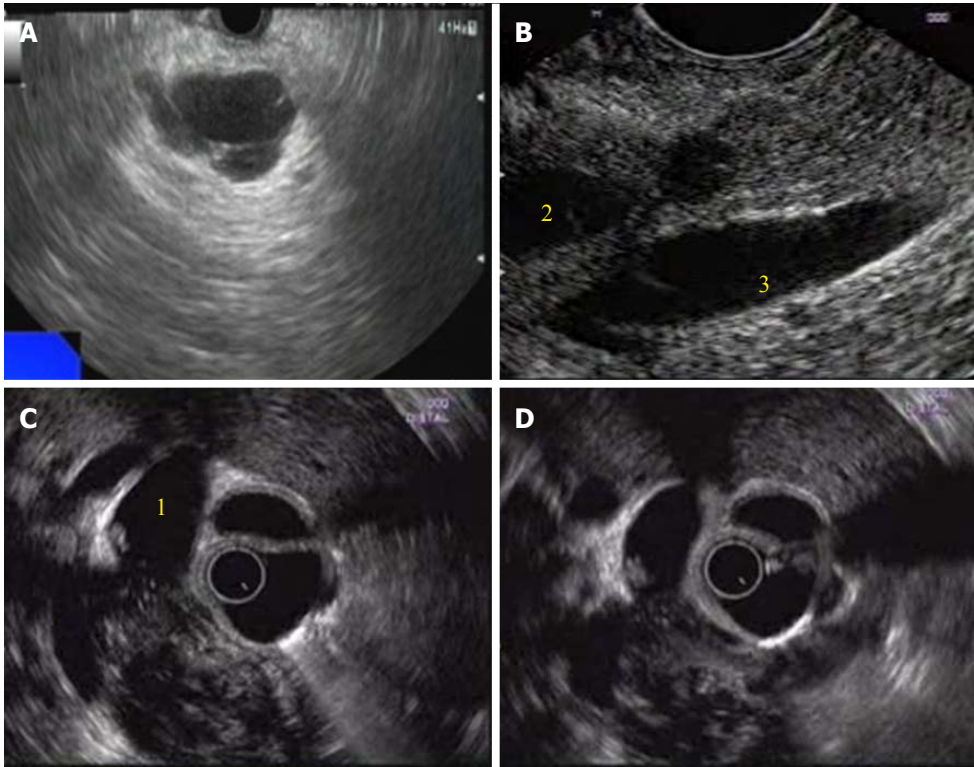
Endoscopic ultrasound appearance of mass lesions in pancreas. A: Serous cystic neoplasm of head of pancreas (HOP); B: Neuroendocrine tumor of head of pancreas with dilated pancreatic duct (2) and adjacent portal vein (3); C: Carcinoma HOP with loss of fat planes with confluence of superior mesenteric vein (SMV) and portal vein and dilated common bile duct (1); D: Carcinoma HOP with common bile duct and SMV infiltration..
